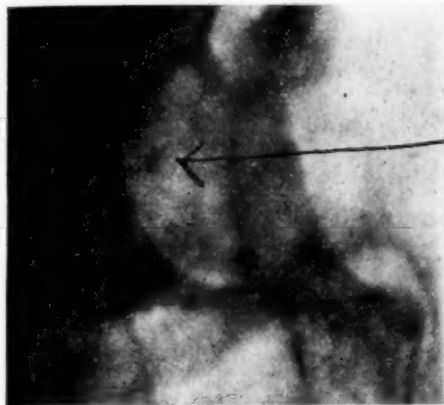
Radiograph showing shadow of foreign body indicated by arrow.
